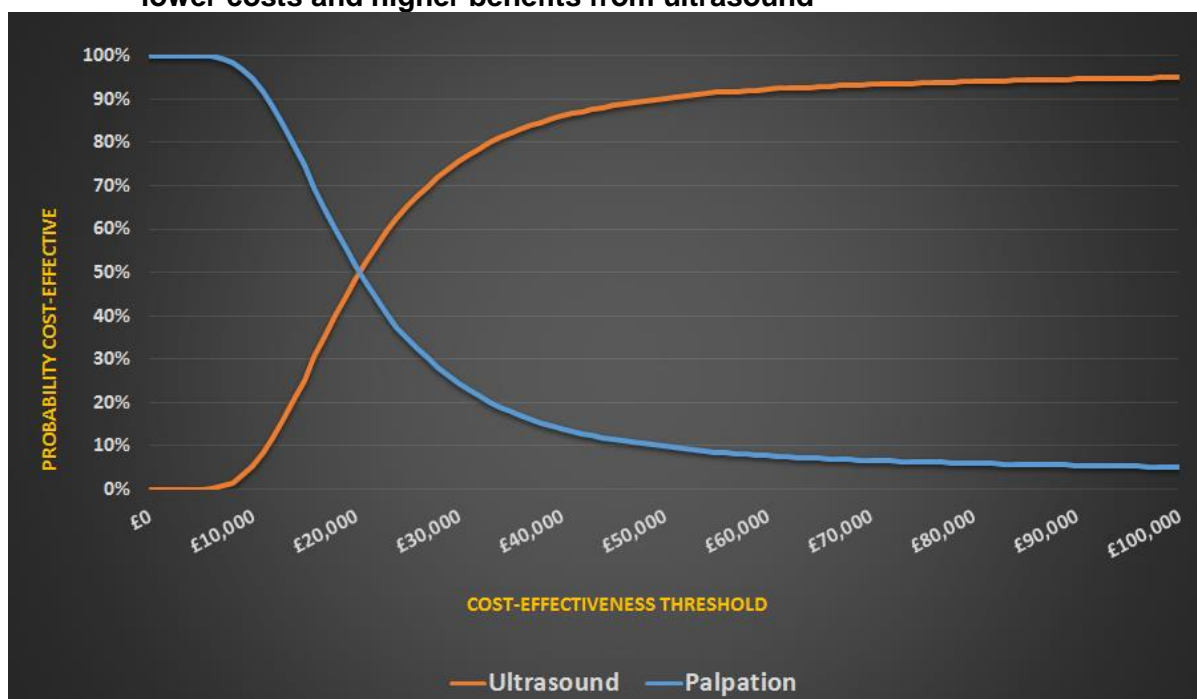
Cost effectiveness acceptability curve for scenario analysis assuming lower costs and higher benefits from ultrasound
